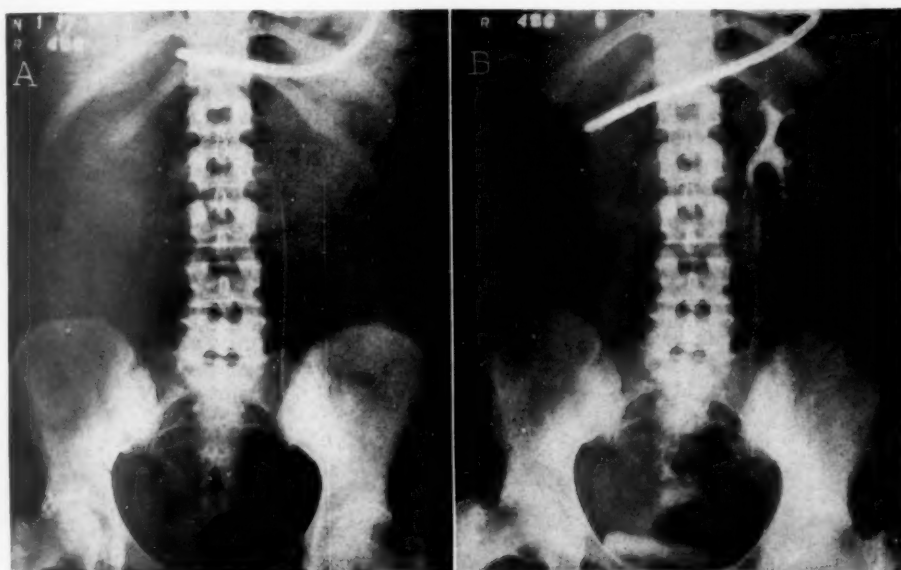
Roentgenograms of patient, L. M., who had 412 cc. of gastric gas aspirated during the 62 minutes of the retrograde pyelography. No increase in intestinal gas from the initial "A" to the final "B" roentgenogram because the stomach was kept empty of air.
